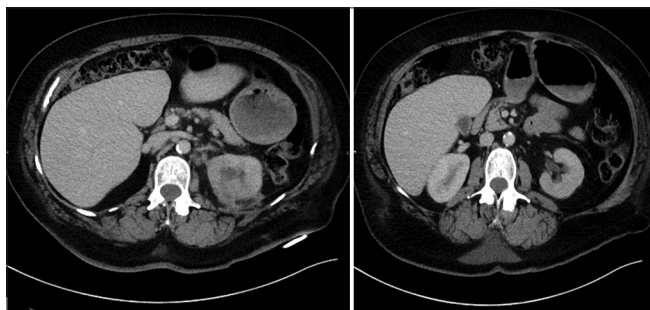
A 60-year-old female who required repeat drainage due to recurrence of flank pain and dysuria 1 week after removal of the initial nephrostomy tube, which was placed due to emphysematous pyelonephritis. CT abdomen with contrast performed following removal of the second drain shows interval improvement with resolution of gas foci and decreased perinephric fluid. Perinephric stranding is still present. More cranial slice is pictured on the left with more caudal slice on the right.
